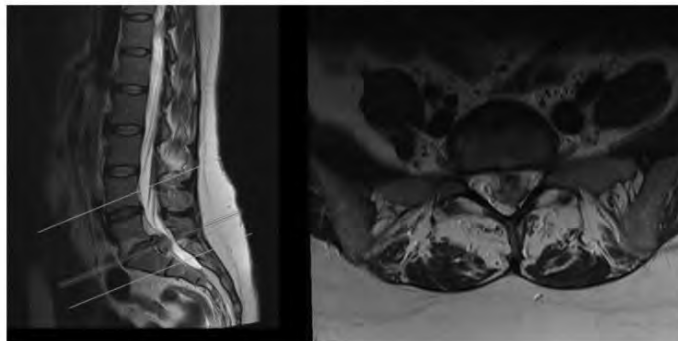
Sagittal and axial T2-weighted slices showing a large disc sequestration at the L5-S1 level. The fragment extends inferiorly behind the S1 vertebral body. Modic changes are also present at the inferior end plate of L5. This patient was included in this study.
